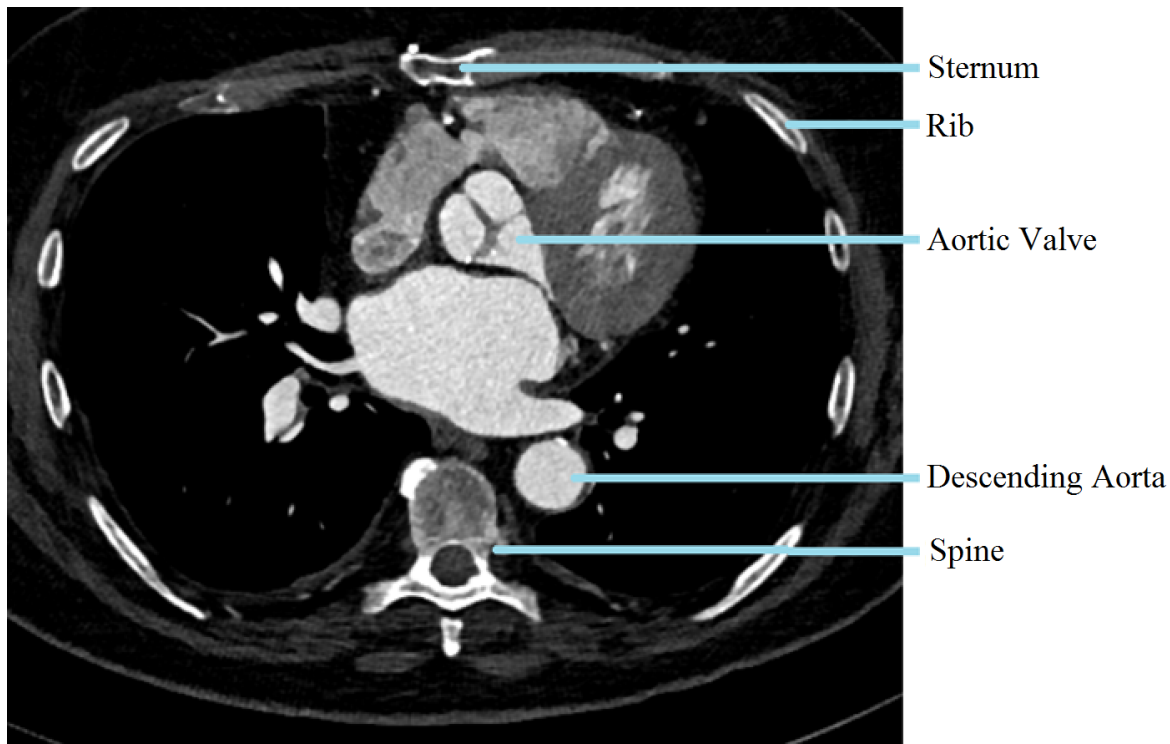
Medical CT image of a human torso. The aortic valve with its leaflet is visible in the centre. Plaques can be seen attached to the leaflets and appear as bright white dots.
